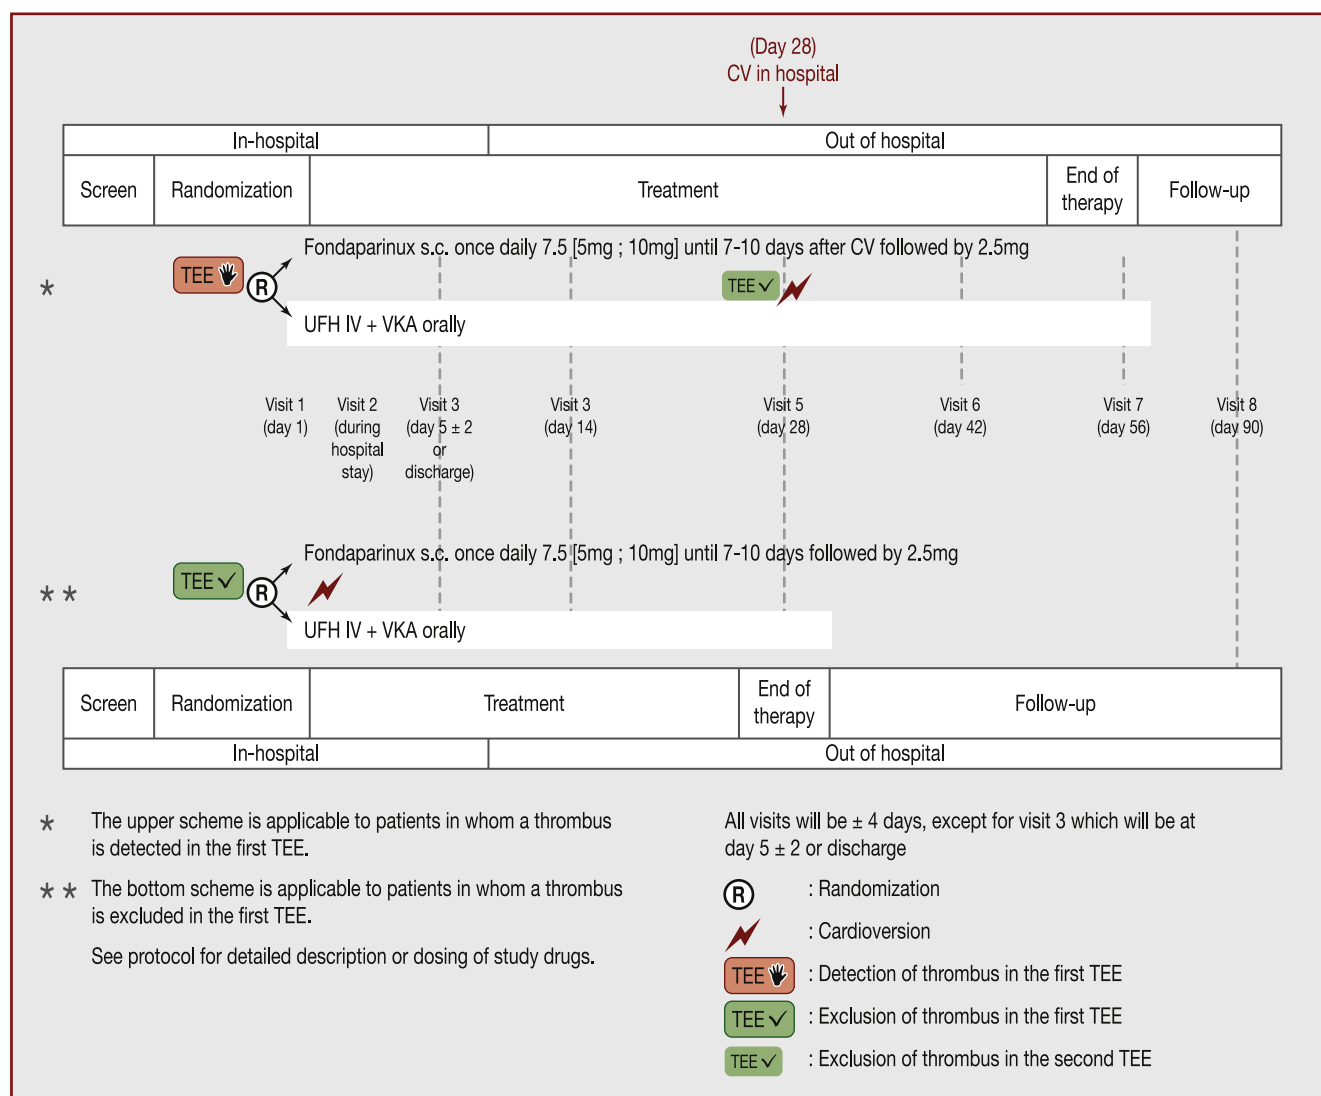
Study design. CV: cardioversion; IV: intravenous; s.c.: subcutaneous; TEE: transoesophageal echocardiography; UFH: unfractionated heparin; VKA: vitamin K antagonist.
